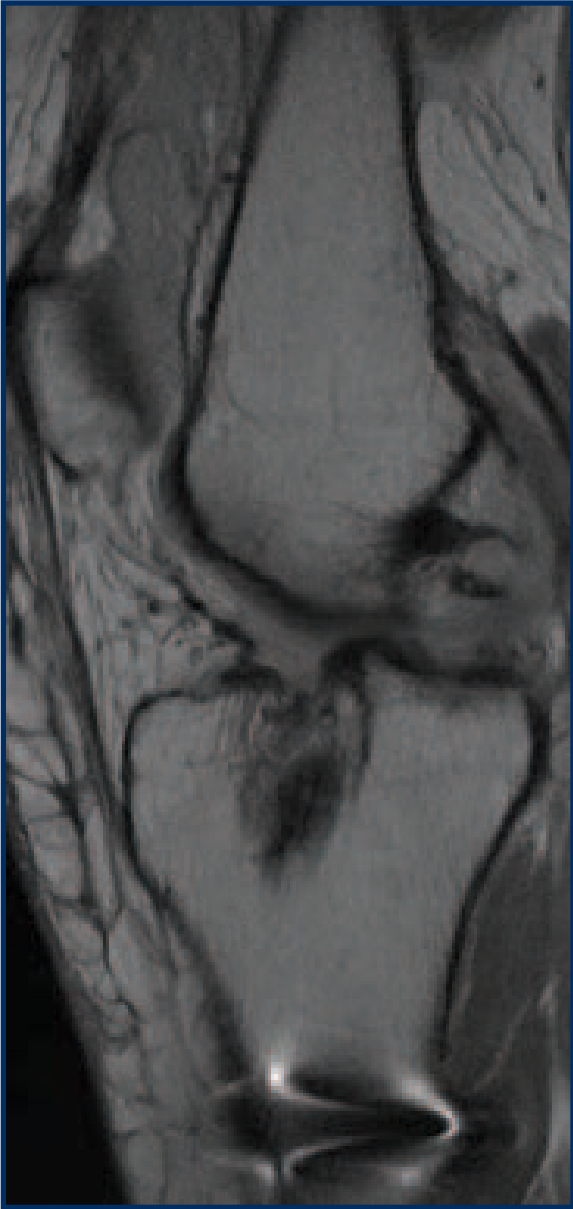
Pre-operative MRI showing failed ACL reconstruction, anterior tibial subluxation, and synovitis.
